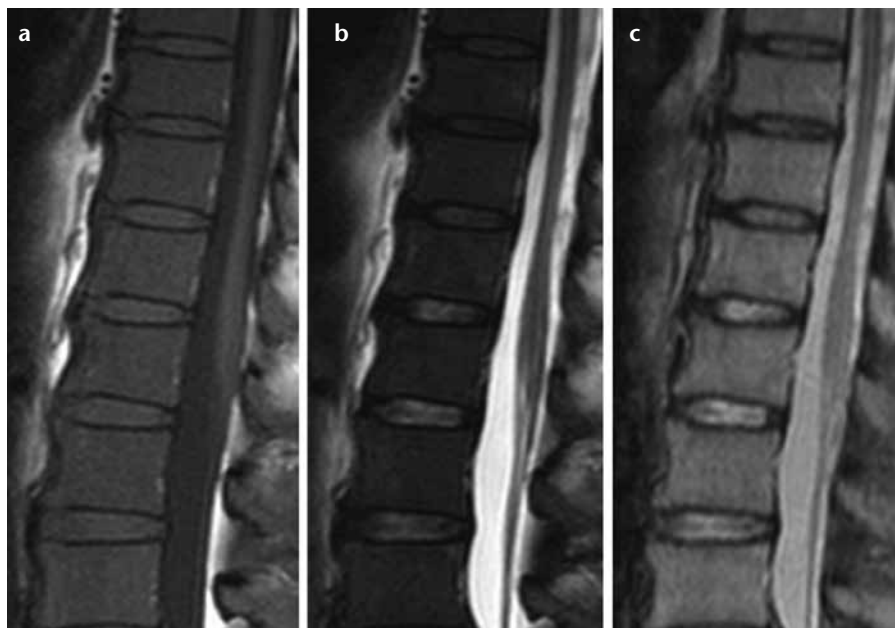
a–c. Myelodysplastic syndrome in a 69-year-old female with pancytopenia. The bone marrow aspiration was a dry tap. The sagittal T1-weighted image (a) shows bone marrow with low to intermediate signal intensity. The sagittal T2-weighted image (b) shows diffusely hypointense bone marrow, and the sagittal STIR image (c) shows no signal suppression. These findings are consistent with myelodysplastic syndrome. The bone marrow biopsy demonstrated hypercellular marrow involving all three cell lineages. The patient later developed acute myelogenous leukemia.
